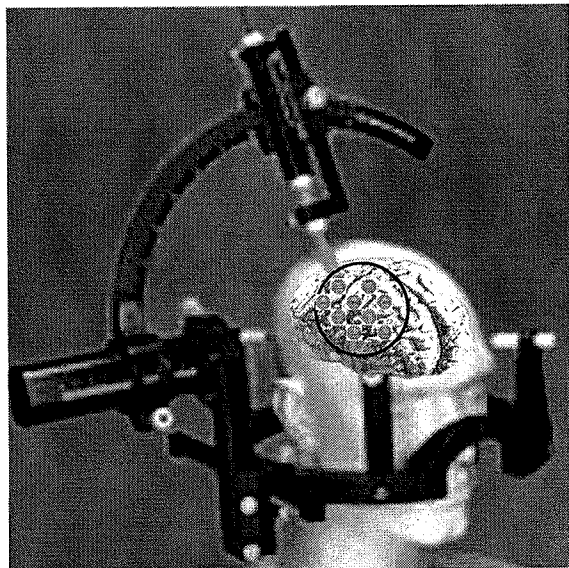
MRI-guided stereotactic injection of adenovirus into CNS tumors in situ. Recombinant adenovirus vectors could be directly injected into multiple areas within the growing tumor or within the margins of a resected tumor using stereotactic injections and MRI guidance. Once injected, the viral vector will express the therapeutic transgene, i.e., HSV1-TK, within the tumor mass or surrounding tissue, thus allowing tumor cell destruction with the anti-herpetic drug ganciclovir.
